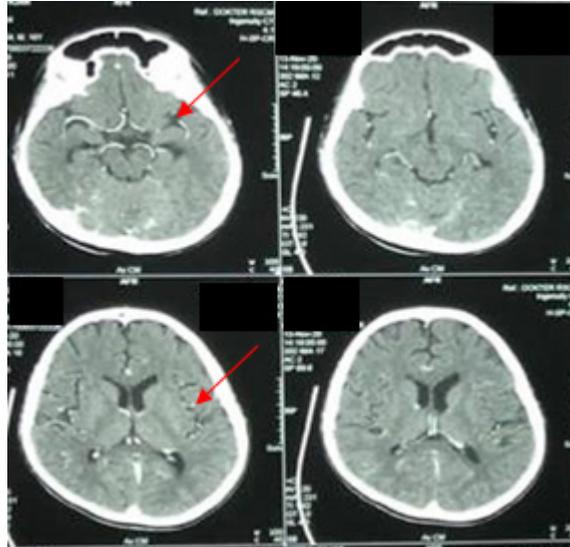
Contrast brain CT scan showing multiple small isodense lesions on the right lentiform nucleus, right internal capsule, and right cerebellum (red arrows)
